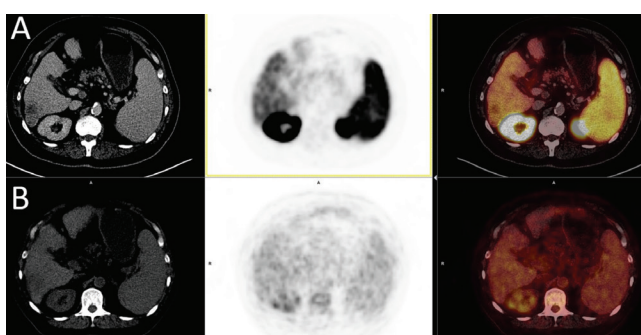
A 62-year-old male with alcohol-induced cirrhosis. Magnetic resonance imaging revealed a mass compatible with hepatocellular carcinoma, showing a typical contrast enhancement pattern (not shown). AFP: 1.648 ng/mL. ⁶⁸Ga-PSMA: (A) SUV_{max}: 9.3; T/L 0.93. ¹⁸F-FDG: (B) SUV_{max}: 4.5; T/L 0.85
